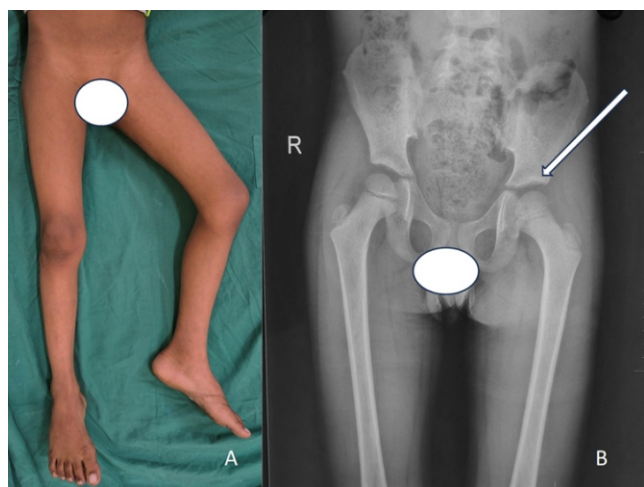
5-year-old child was diagnosed with septic arthritis of the left hip joint. A. Clinical photograph shows the flexed, abducted and externally rotated position of the left hip joint. B. Unremarkable radiograph of the left hip joint early in the infection (marked by arrow).
